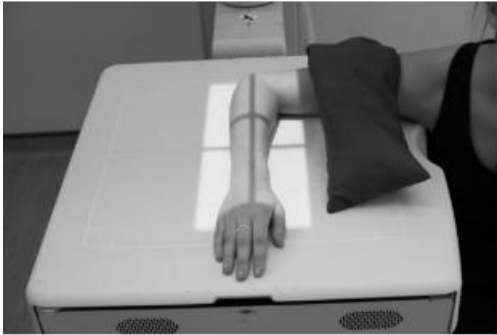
Positioning of AP projection radiograph image adopted from Clark's positioning in Radiography (Clark, 2016).
